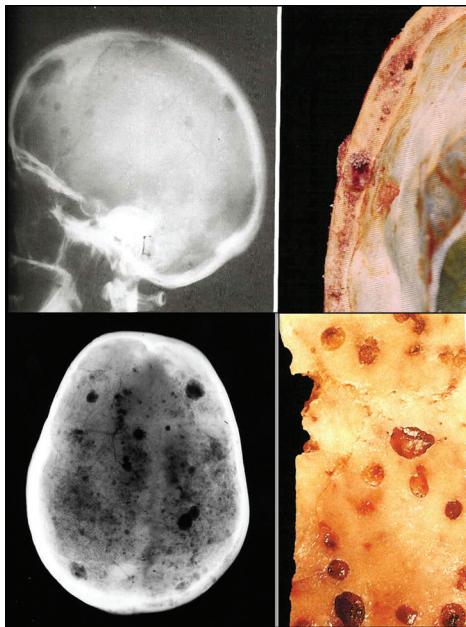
Multiple myeloma bone disease (MMBD) is characterized by excessive bone destruction accompanied by absent new bone formation. In the left panel, the patient has multiple visible tumor lesions in the calvaria as shown by radiography. The right panel shows a segment of skull with myeloma tumor growth in the calvarial bone. (Figure courtesy of Dr. Mankin, Massachusetts General Hospital.)
